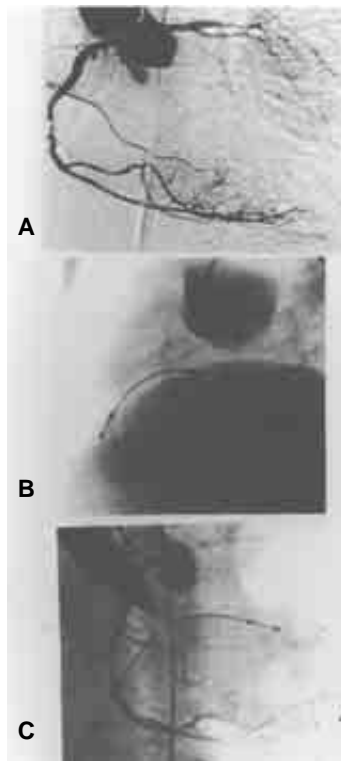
A) Right coronary angiography in ODA. A type C proximal lesion is observed in the right coronary artery. It is simultaneously visualized the aorta, and left coronary artery. B) Lateral view of a chest roentgenogram. It is observed contrast medium retained in the aortic wall, as well as a pacemaker in the right ventricle. C) Right coronary angiography after the angioplasty and the implant of three stents.
